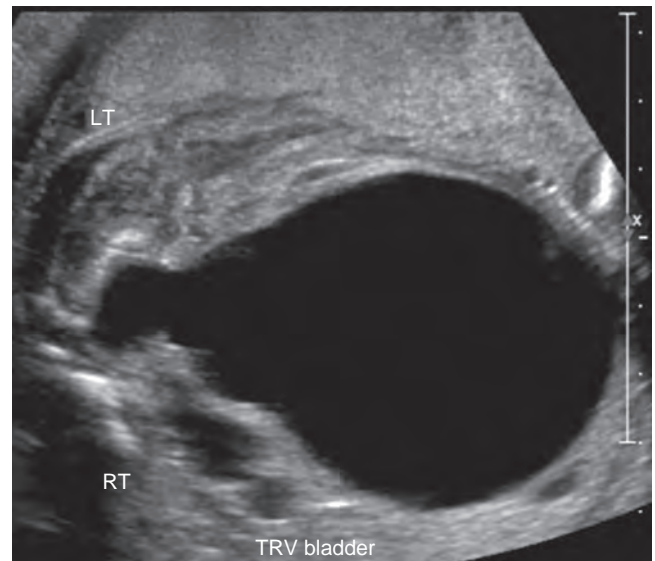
Sonogram of fetal bladder shows a thickened bladder with dilated posterior urethra below, suggesting the “keyhole sign.” LT, left kidney; RT, right kidney; TRV, transverse. (Courtesy Dr. Mark P. Johnson, Children’s Hospital of Philadelphia.)
